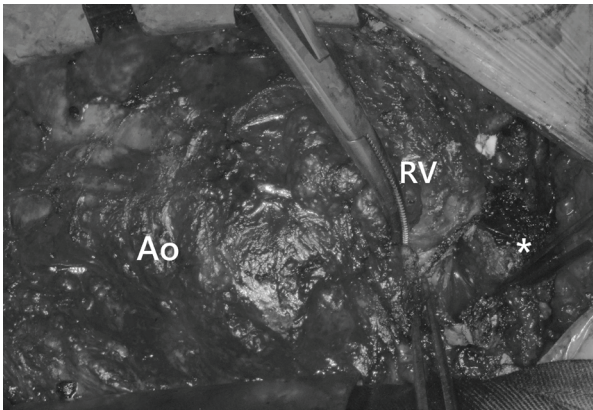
The calcified pericardium strongly fixed on the heart surface is gently removed from the heart using an electric knife and ultrasonic scalpel. Ao: aorta; RV: right ventricle; *thick calcified pericardium on the inferior portion of the heart.
